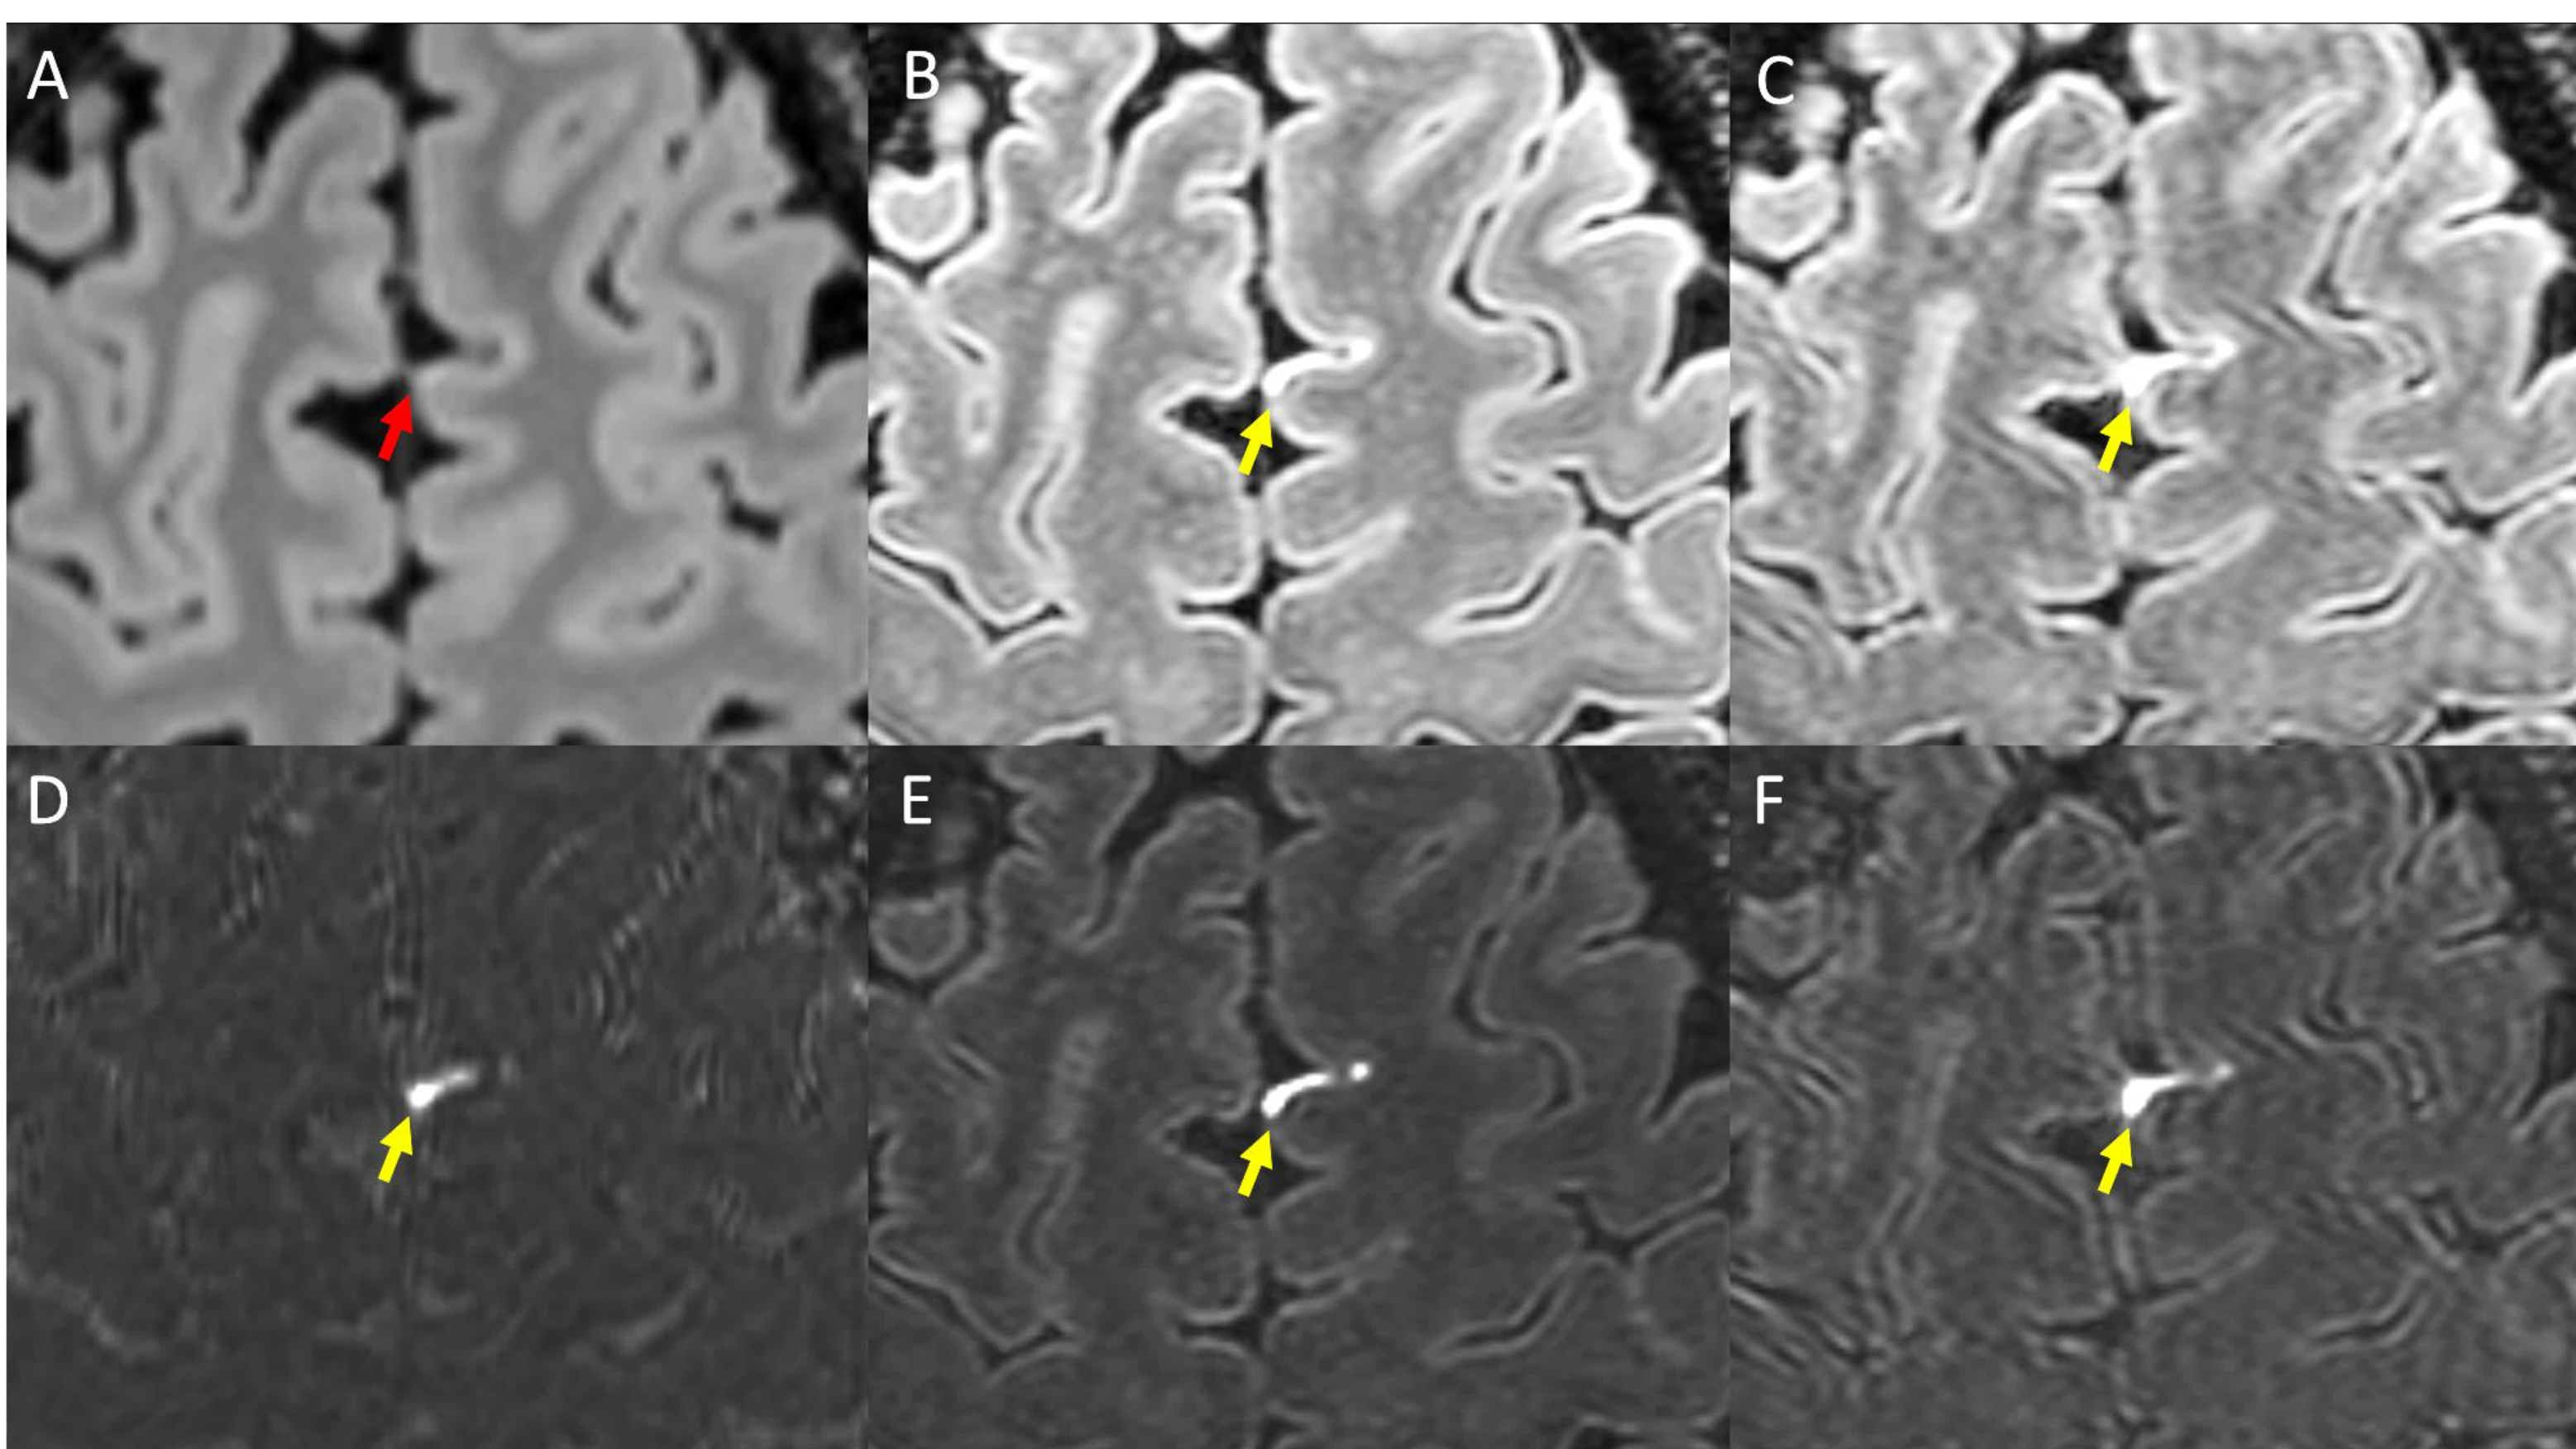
Example of LME as visualized on various Gd+ imaging protocols. Shown is Gd+ Delayed 3T FLAIR (A), Gd+ Early 7T FLAIR (B), and Gd+ Delayed 7T FLAIR (C). Also shown are subtraction maps associated with each (D, E, F, respectively). Yellow arrows indicate a focus of LME readily visible, but which is barely visible on Gd+ Delayed 3T FLAIR (red arrow). Note that although the focus is seen on Gd+ Early 7T FLAIR (B, E), it is thicker/more prominent on Gd+ Delayed FLAIR (C, F).
